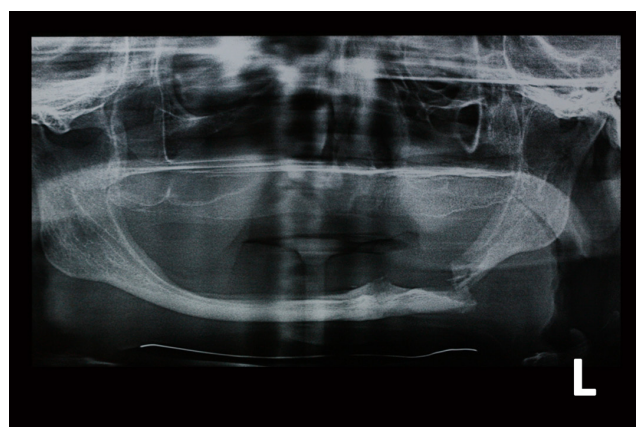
Radiographic view showing a mandibular body fracture.
